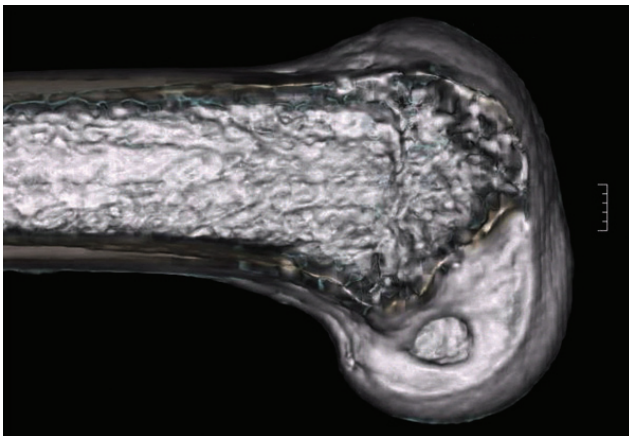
A three-dimensional computed tomography image showing the appropriate femoral attachment site of the anterior cruciate ligament graft.
